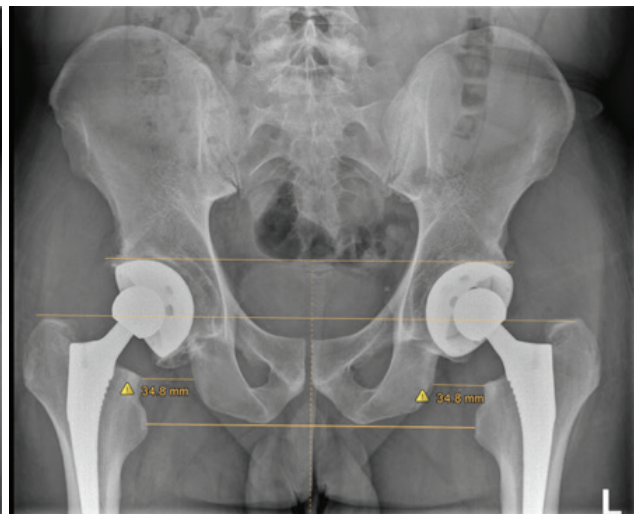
Anteroposterior X-ray image after bilateral hip replacement surgery. The line that connects the tops of two acetabular components and the line that connects two tops of greater trochanters (through the center of implanted femoral heads) are parallel to the bottom pelvic line that connects two lesser trochanters. The higher inclination of the acetabulum was compensated by the use of an elevated polyethylene insert not to damage the stability of the prosthesis.
